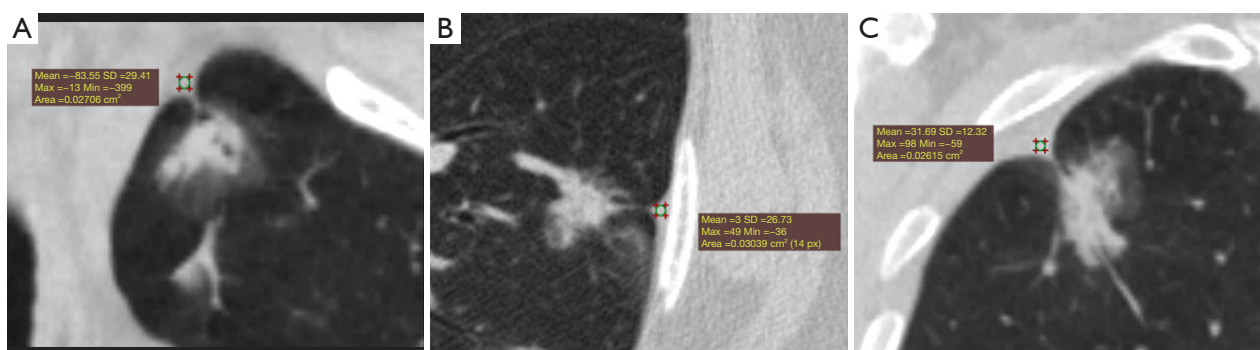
The density changes of the pleura in indirect pleural contact type. (A) A 76-year-old man presented with mGGNs in the left upper lobe and fat density in the mediastinal pleural indentation (Type C). (B) A 54-year-old female presented with mGGNs in the left lower lobe and water density in the costal pleural indentation (Type D). (C) A 57-year-old female presented with mGGNs in the right upper lobe and soft tissue density in the costal pleural indentation (Type E). SD in figures means standard deviation of CT value. CT, computed tomography; mGGNs, mixed ground glass nodules.
